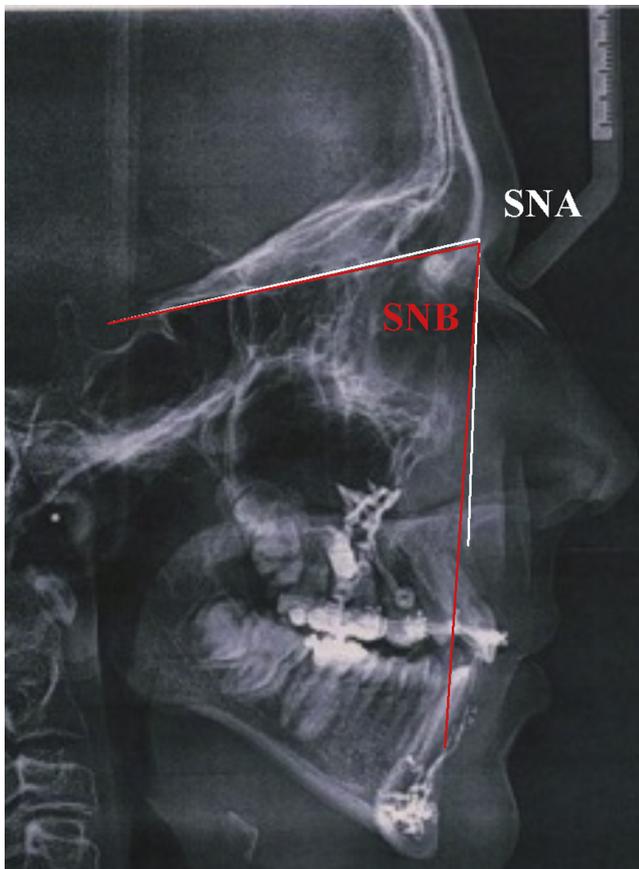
Initial values of SNA and SNB on lateral cephalometric radiograph.
